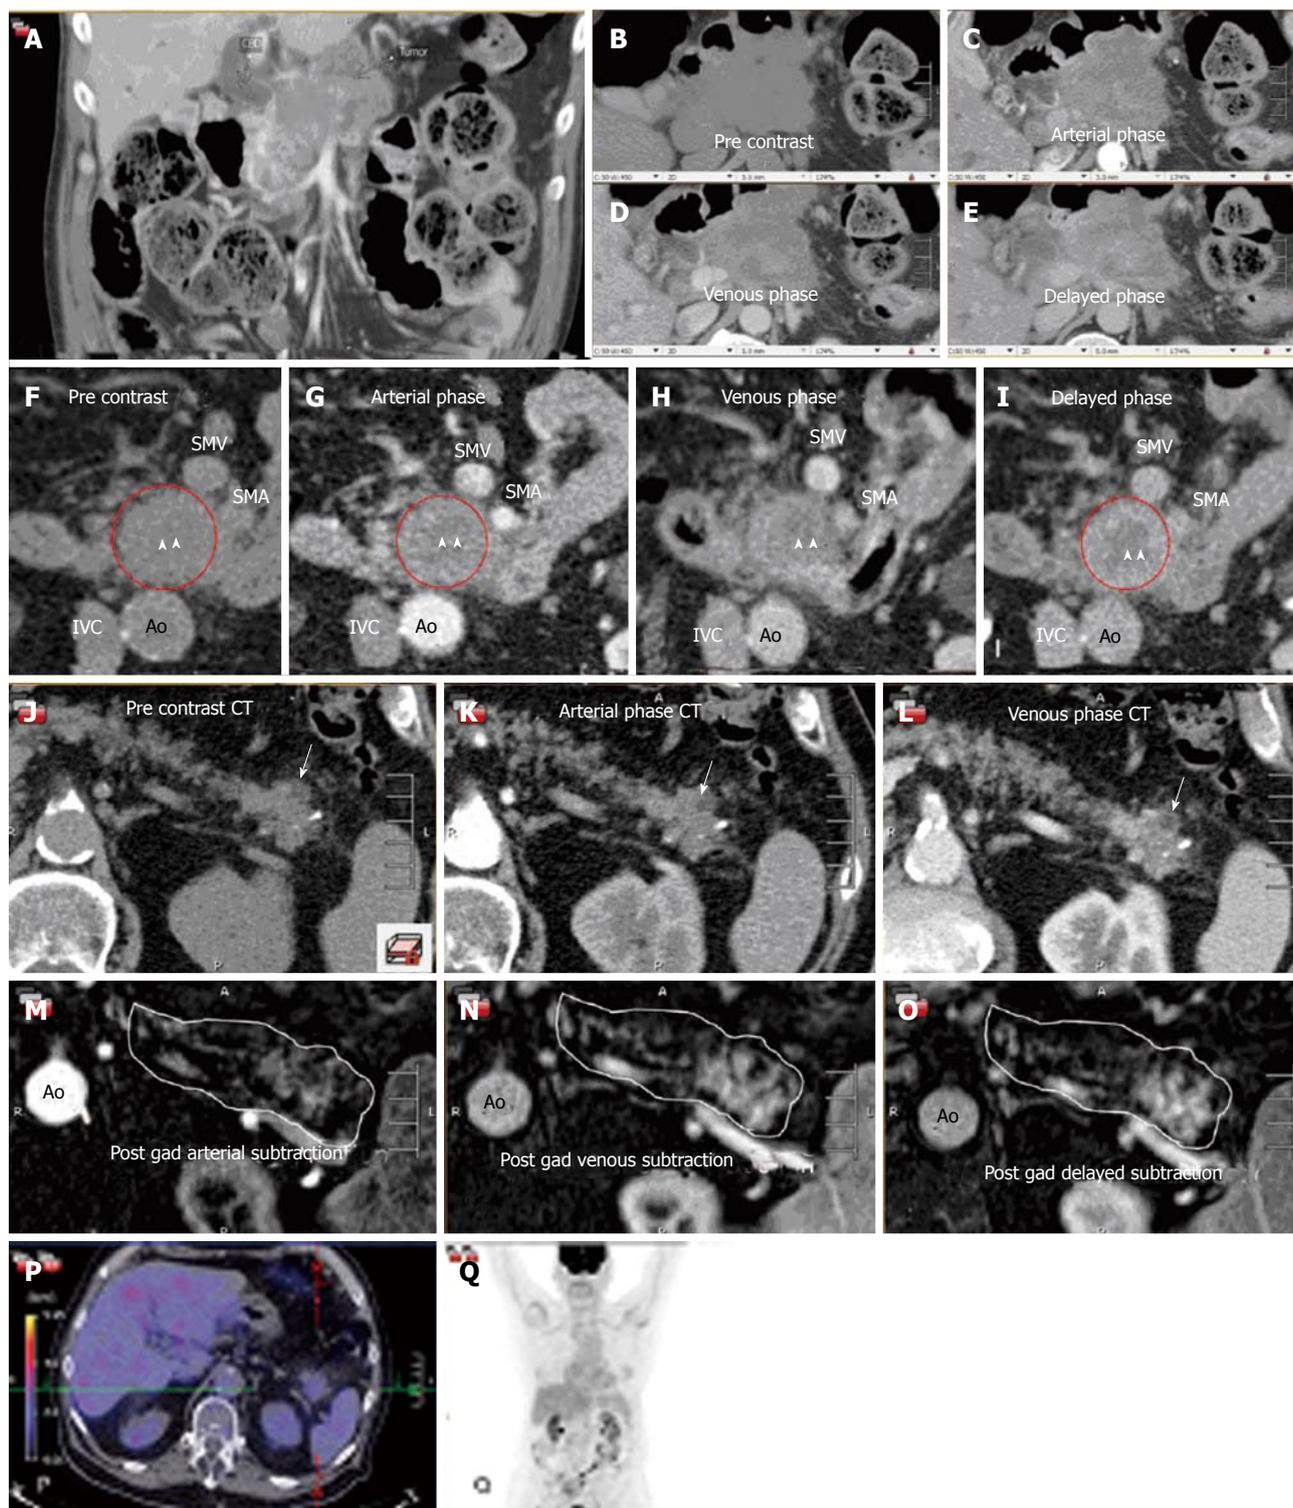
Collection of images from three separate patients with adenosquamous carcinoma of the pancreas. The typical complex enhancing mass and mixed morphology of necrosis and enhancing tissue is demonstrated in this figure. A-E are taken from a four phase contrast enhanced CT (pre-contrast, arterial, venous and delayed images). This type of scanning technique can be helpful to define the tumor and its invasion into surrounding structures. A-E represent a coronal (A) and axial (B-E) images through a large, infiltrating, necrotic tumor with islands of slow enhancement (B-E). Note the islands of soft tissue enhancement increasing from arterial to delayed phase contrast enhanced CTs. These features are usually signs of very aggressive tumors. In another subject (F-I) there is again a central area of necrosis (arrowheads) surrounded by a ring of slowly enhancing tumor (red circle). Note the relative lack of surrounding soft tissue infiltration compared to the tumor on Panels A-E. Panels J-O are taken from a third subject and are an example of an atypical adenosquamous carcinoma involving the pancreas tail with a slowly enhancing, non-infiltrating lesion both on CT (J-L) and post gadolinium subtraction MRI (M-O). The white outline in Panels M-O outlines the contour of the pancreas with the enhancing lesion seen towards the tail of the pancreas. There is a small focus of necrosis present (arrow), a feature typical of adenosquamous carcinoma of the pancreas. The corresponding FDG PET/CT (P and Q) is unusual in that it shows that this mass is not hypermetabolic unlike most adenosquamous pancreas carcinomas. Ao: Aorta; IVC: Inferior vena caval; SMA: Superior mesenteric artery; SMV: Superior mesenteric vein.
